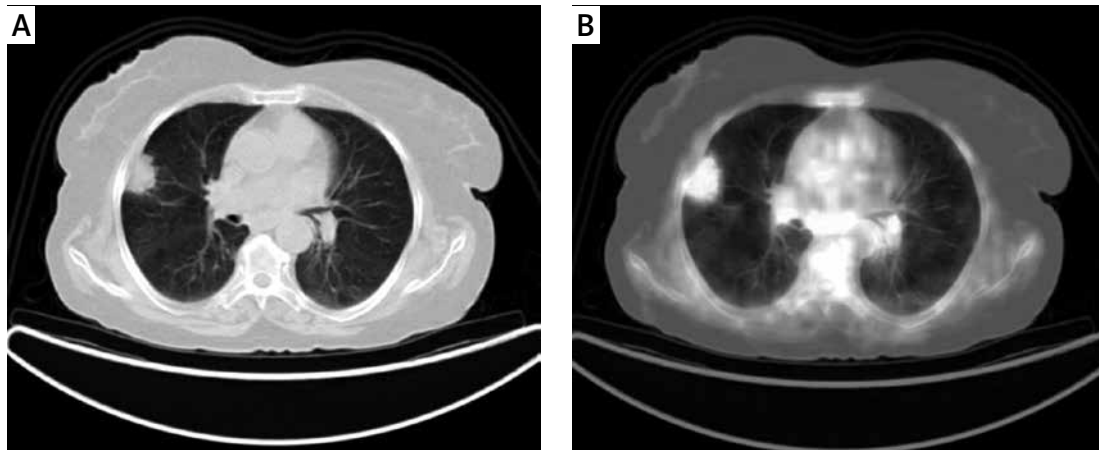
A – CT image showing a solitary pulmonary nodule in the anterior segment of the upper pole of the right lung. B – On ^{18}F -FDG PET/CT, increased focal uptake was seen in the pulmonary nodule, suggesting a malignancy (SUVmax 4.2 kBq/ml)
